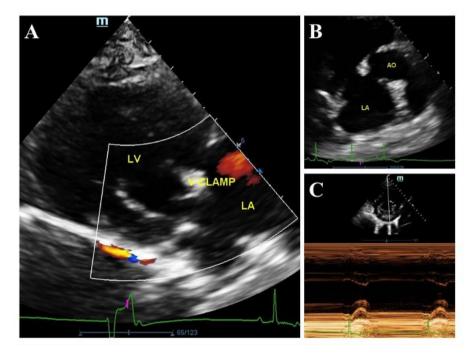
Color Doppler echocardiography shows a V-clamp device with no turbulent flow into the left atrium during systole (A). Two-dimensional view of the left atrium and aorta on the right parasternal short axis view (B). Two-dimensional and M-mode echocardiography shows the left ventricular internal diameter on the right parasternal short axis view at the level of the head of the papillary muscle (C). LV=left ventricle; RV=right ventricle; RA=right atrium; LA=left atrium; Ao=aorta; MR=mitral regurgitation
